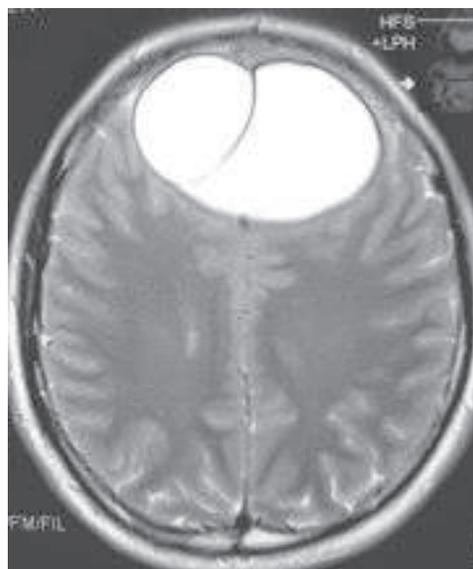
T2WI of MRI showing fine hypointense smooth and regular septa between two larger cysts at most parts
